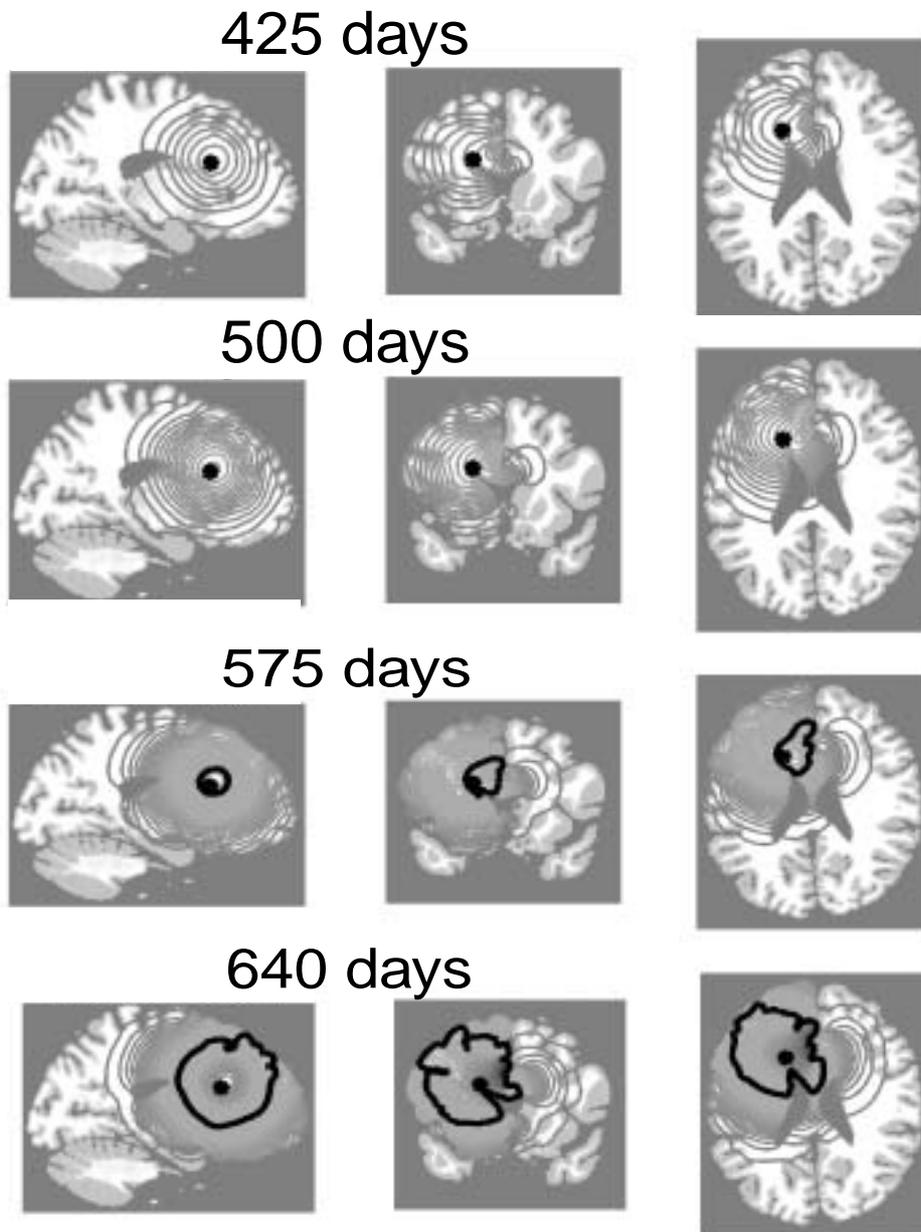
Contour plot of the tumor cell density of a virtual glioma at multiple time points following the initiation of the lesion at the asterisk. The images are cross-sections of the brain intersecting at the asterisk. The outermost contour corresponds to a detection threshold 80 times more sensitive than MRI technology (thick black curve).
